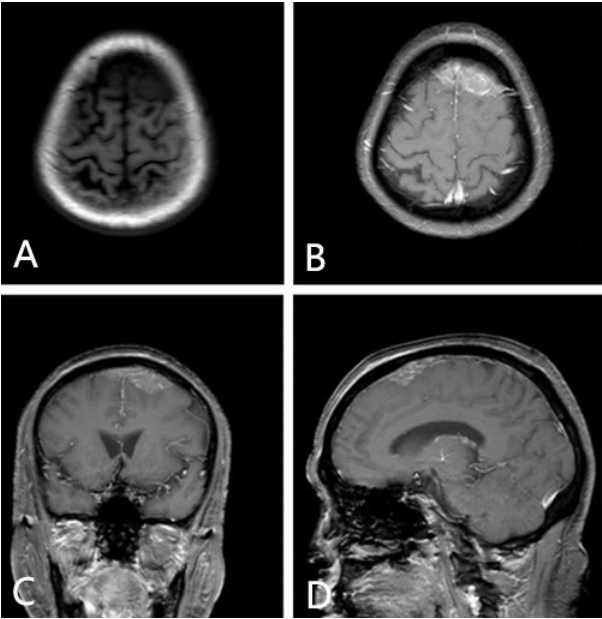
双侧额部硬膜前列腺来源的转移性病变术前 MRI 表现
